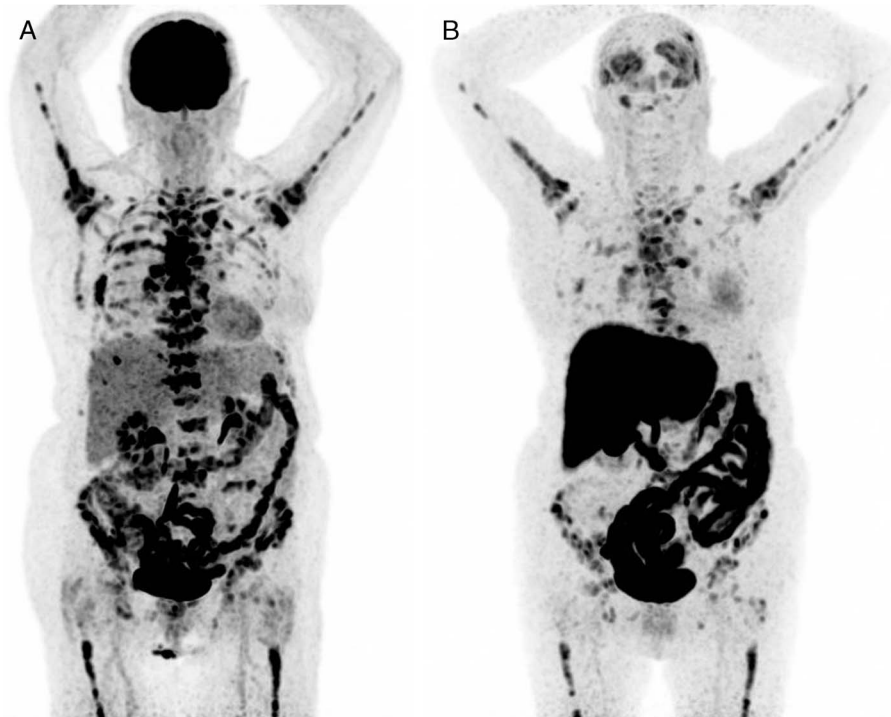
Here, we present images of a 76-year-old woman with estrogen receptor (ER)-positive metastatic breast cancer. A whole-body $[^{18}\text{F}]$ -FDG PET/CT, performed for disease staging according to guidelines,¹ showed extensive metastatic disease in bone, bone marrow, mediastinal lymph nodes, and physiological $[^{18}\text{F}]$ -FDG uptake in the brain (A: maximum intensity projection image). The patient showed disease progression after 2 lines of endocrine treatment. To assess ER status of metastases, PET imaging with 16α - $[^{18}\text{F}]$ fluoro- 17β -estradiol ($[^{18}\text{F}]$ -FES) was performed as part of a clinical trial,² showing high ER expression in the known metastases, but also increased $[^{18}\text{F}]$ -FES uptake in the dural region, interpreted as possible dural metastases (B: maximum intensity projection image). The SUVmax values of the dural lesions ranged between 3.6 and 4.4. In literature, an SUVmax cutoff value of ≥ 2.0 is considered as ER-positive.^{2,3} These lesions were not detected with $[^{18}\text{F}]$ -FDG PET/CT imaging, and associated clinical symptoms were lacking at the moment the scans were performed. Tumor progression was confirmed on all imaging modalities, and a third-line endocrine treatment was started.
